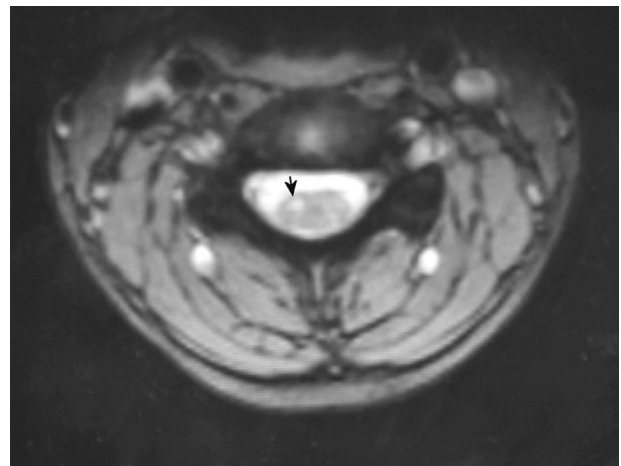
Magnetic resonance imaging scan of the patient in case 11. The hyperintense area is marked by an arrow representing the lesion on the anterior horn at the C5 level.
